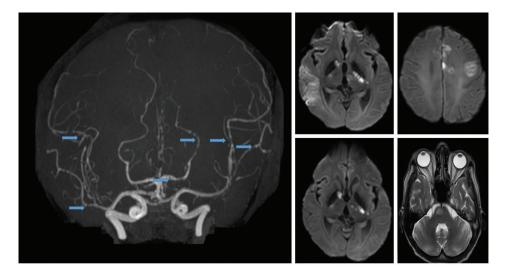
MR angiography and MRI images. Left panel shows an intracranial MR angiography with blue arrows depicting areas of stenosis. Right panels (diffusion-weighted MRI) show cortical and basal ganglia infarcts. The bottom right image is a T2-weighted MRI image showing a bulky right pontine hyperintensity
